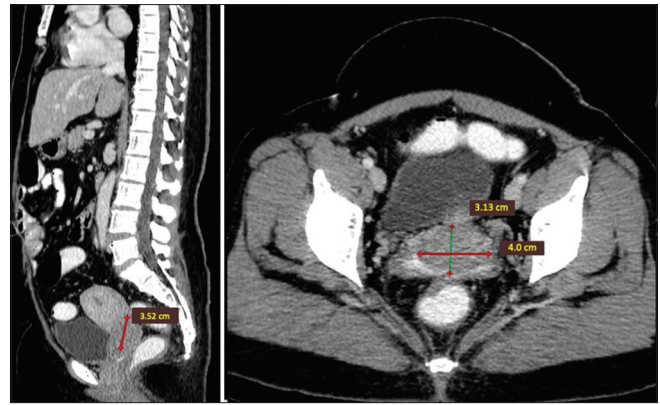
Abdominopelvic computed tomography scan with contrast: Hypodense, distinct mass measuring 3.13 cm × 4.0 cm × 3.52 cm
